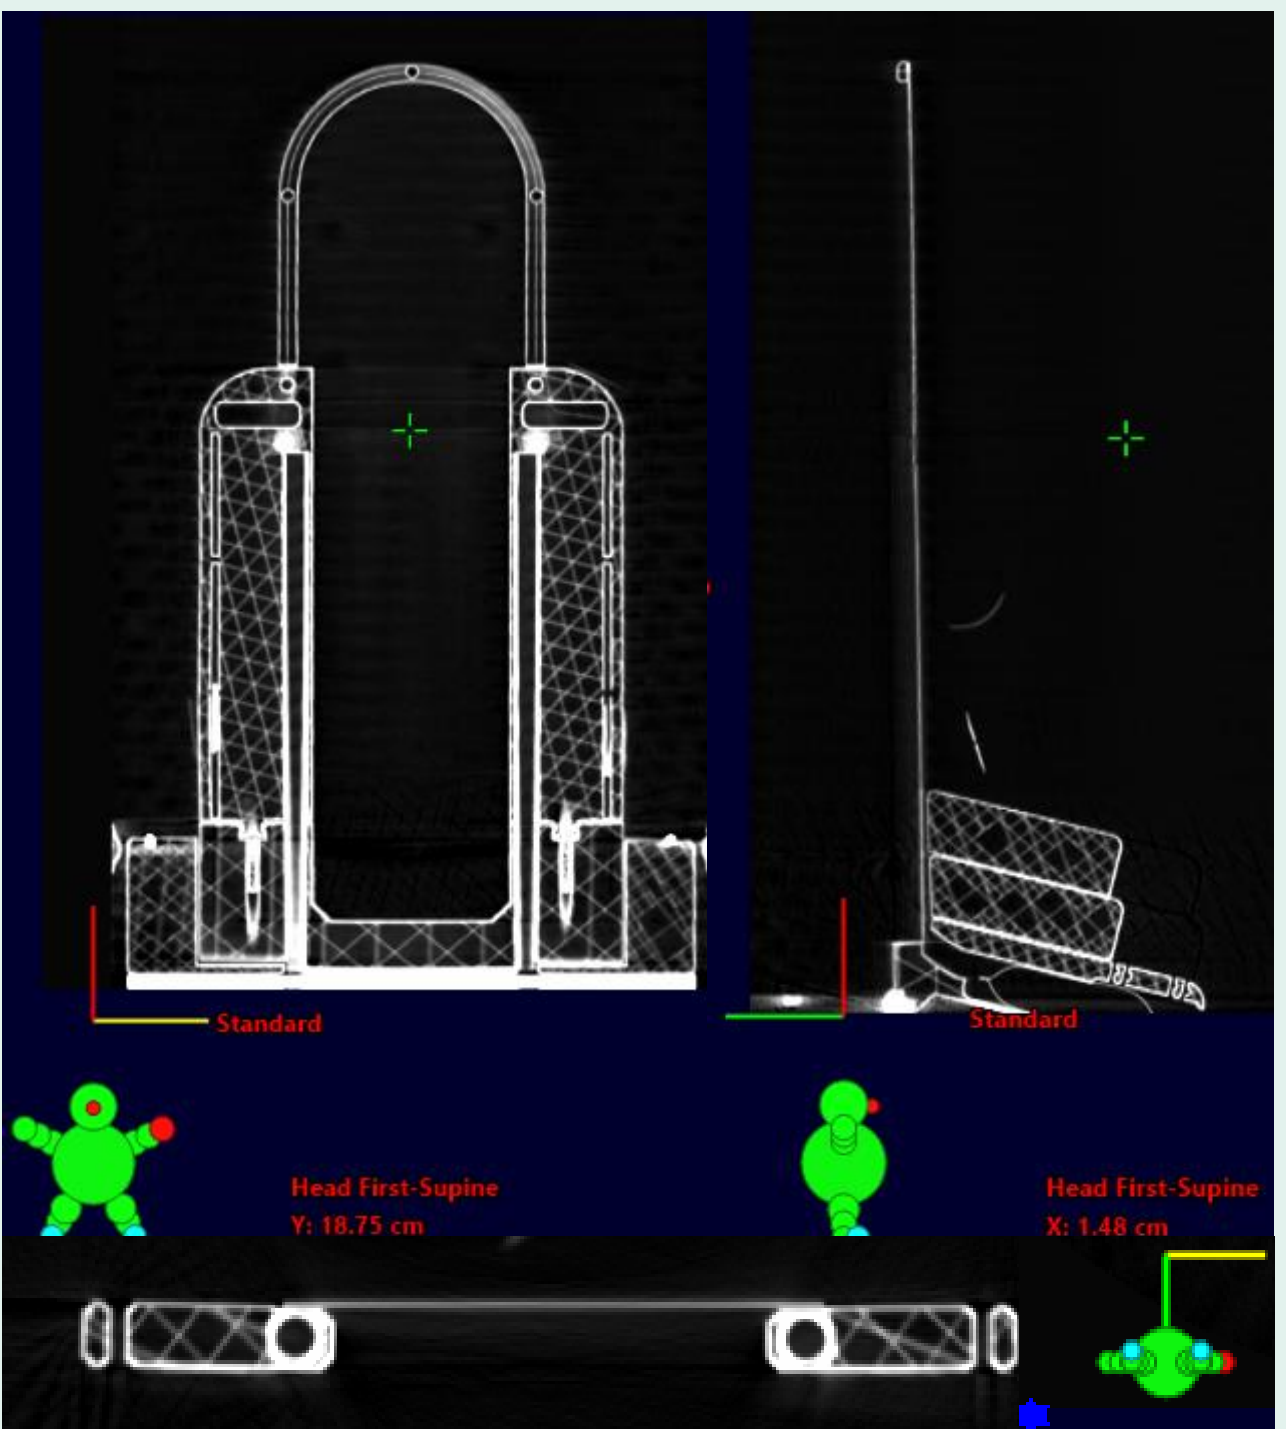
Upright CT scan of tilting pediatric chair verifies compatibility and CT number.
